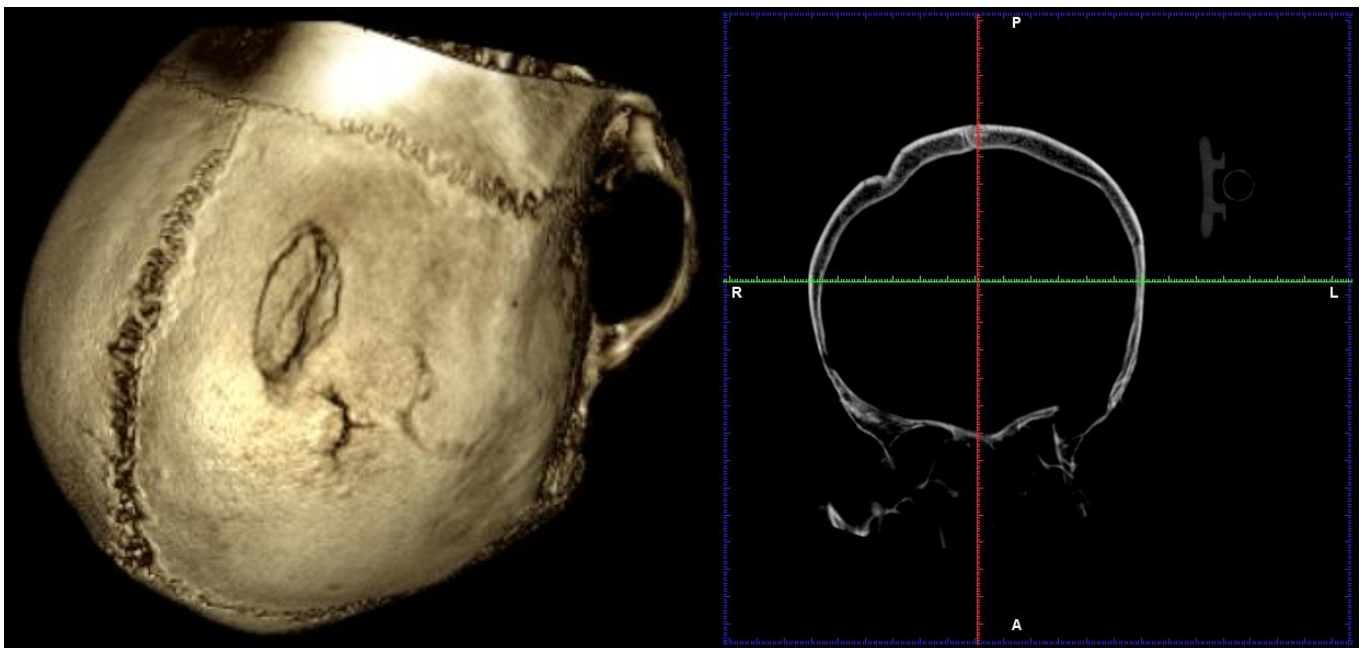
CT scan of depressed fracture. Note that the x-ray image (right side) shows that the lesion penetrates the outer table of the cranium, but leaves the inner table intact.
